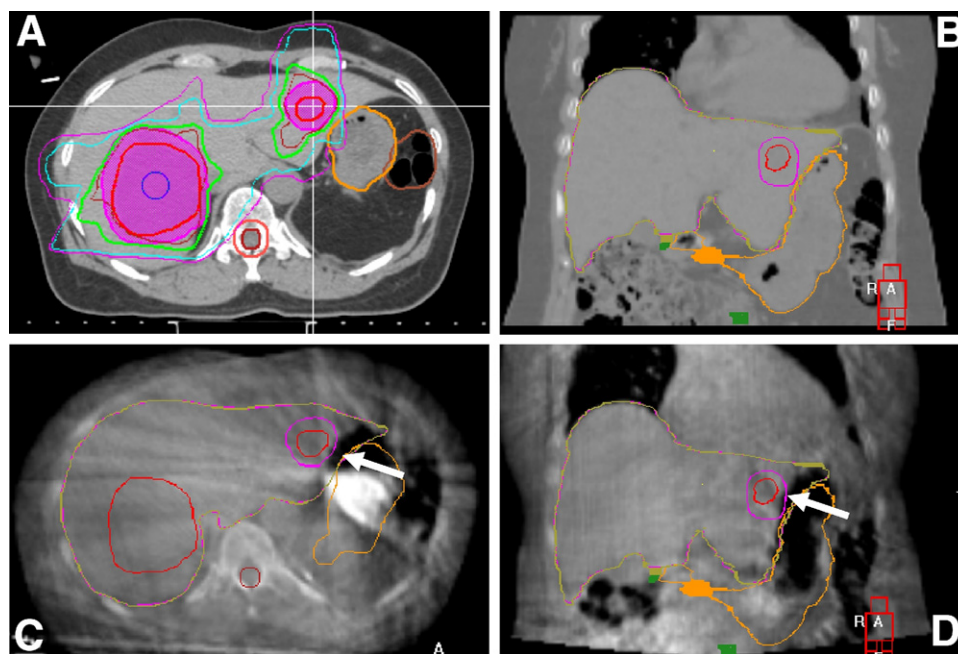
SBRT for metastases in left and right liver lobes. (A and B) Planning CT scans: 33 Gy (in 6 fractions) isodose line (green) is covering the PTVs (pink shadows) and avoiding the stomach (orange) on the planning CT. (C and D) Third-fraction CBCT scans: a random change in gastric filling (arrows), along with a small liver volume reduction, pushed the left lobe medially, whereas the right lobe alignment was acceptable. Without replanning the patient to account for the change, the dose to the stomach would have been higher than acceptable, and the left lobe tumor would potentially have been underdosed.
